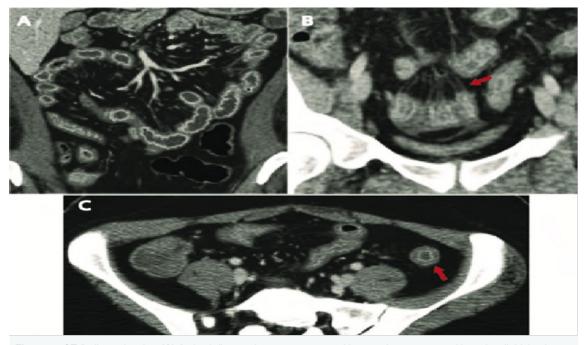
CT* findings showing (A) Active inflammation causes mucosal hyperenhancement and bowel wall thickening greater than 3mm. (B) Engorgement of the vasa recta adjacent to an inflamed loop of bowel is a specific finding in active *CD* and has been coined the "comb sign." (C) Submucosal edema yields a characteristic "target sign."
